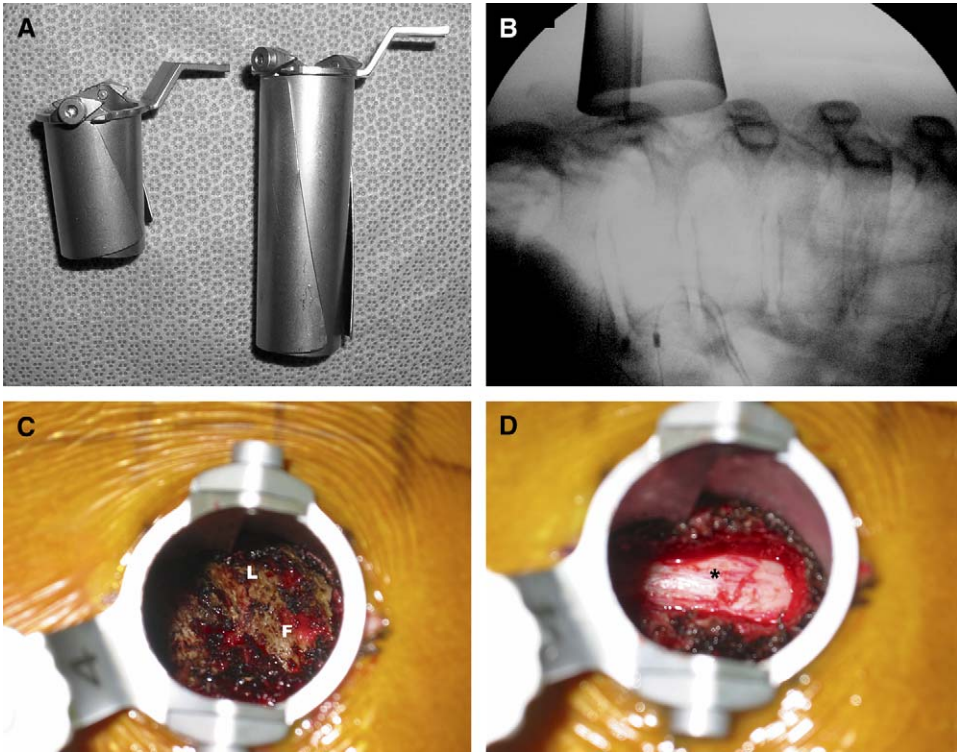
(A) Two examples of the X-Tube retractor (Medtronic Sofamor-Danek, Memphis, Tennessee). The superficial aperture is 2.5 cm in diameter. Note the hinge at the top of the tube that allows the base to be expanded, permitting an approximately 4-cm long field at the depth of the retractor. (B) Intraoperative lateral fluoroscopic radiograph demonstrates postexpansion positioning of the X-Tube for a thoracic IDEM tumor resection. (C) Photographic view through X-Tube after initial exposure of a right-sided approach reveals a typical appearance of the thoracic lamina (L) and facet (F). Right is rostral, and the top is medial. (D) Photographic view through the X-Tube after completion of bony removal shows typical dorsal dural exposure. The midline of the dura is marked (\*).
